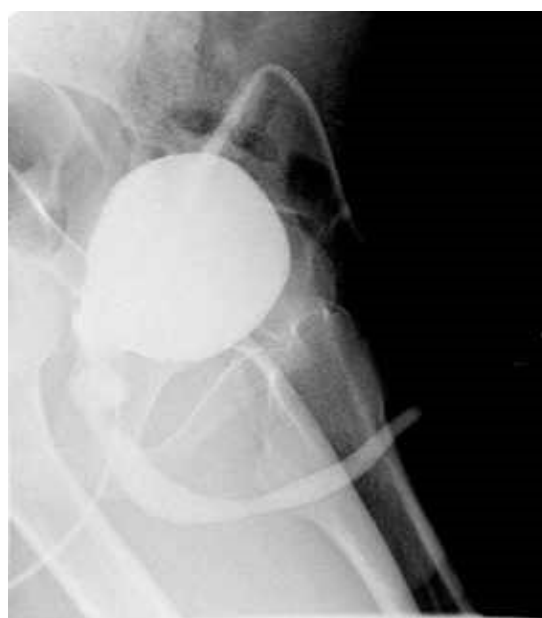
A post-operative cystogram shows a dilated posterior urethra, but no reflux into the ultrasound and endoscopy identified cystic structure attached to the back of the posterior urethra.
